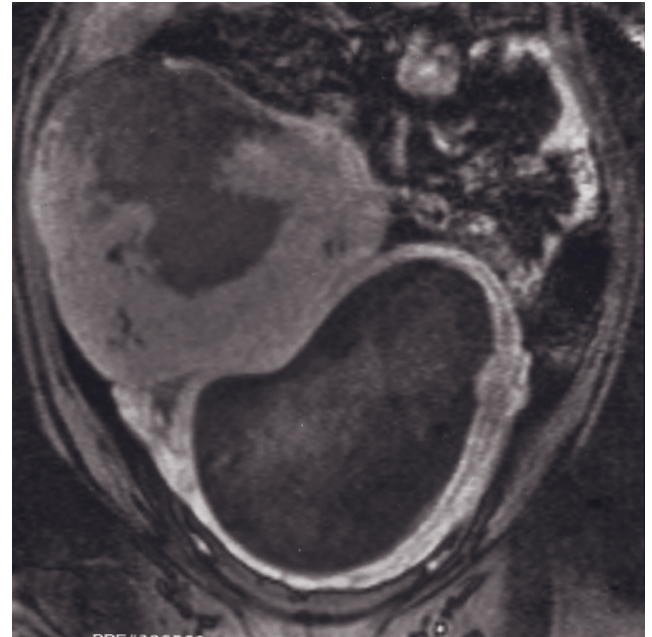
Large uterine leiomyoma in two pregnant patients. Coronal (*a*, anterior; *b*, posterior) and sagittal (*c*, *d*) T2-weighted SS-ETSE images. The large uterine leiomyoma (arrows, *a*, *b*) shows multiple foci of increased signal intensity corresponding to areas of degeneration. Note also the normal pregnancy and placenta (black arrow, *a*). Coronal SS-ETSE (*e*) and coronal
